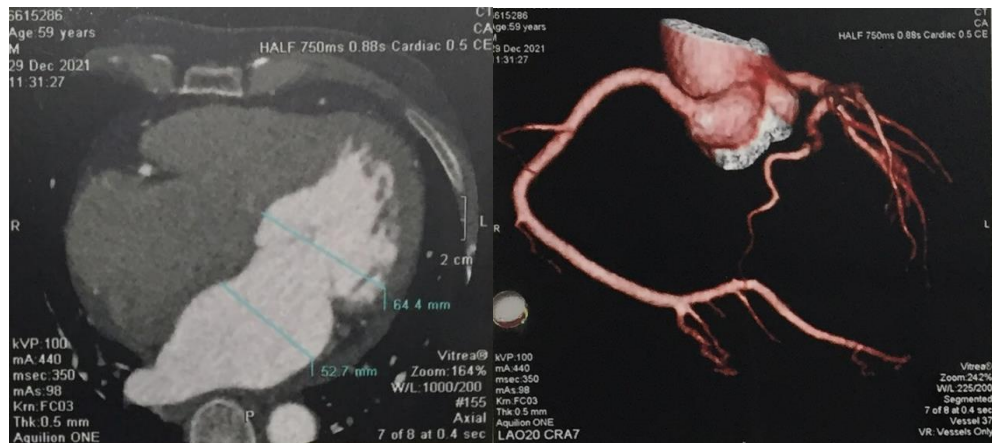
Cardiac CT revealed dilated left ventricular, dilated left atrium. Normal coronary arteries.
